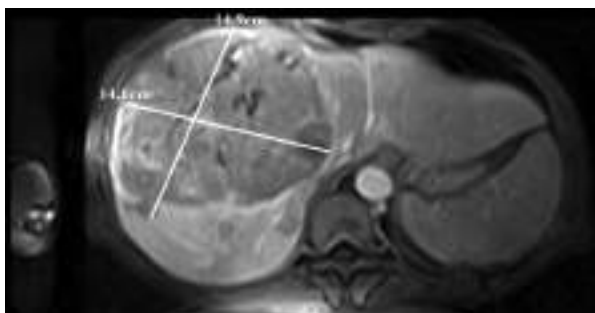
Abdominal MRI at the time of HCC diagnosis (August 2019)
